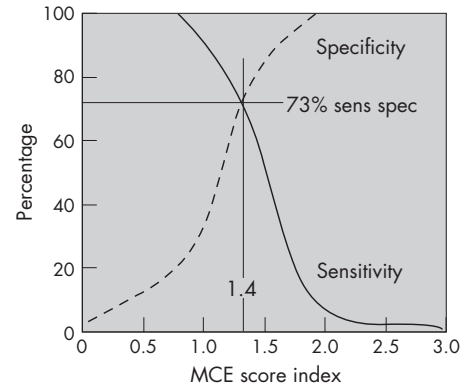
Receiver operating characteristic analysis curves of 1-week myocardial contrast echocardiography (MCE) score index showing the ideal cut-off of 1.4 with sensitivity and specificity of 73% in predicting left ventricular dilatation.
